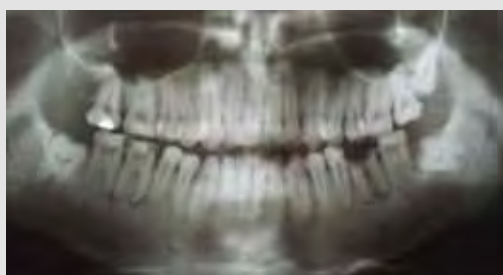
Panoramic radiography before treatment reveals a very thin enamel layer, normal roots and pulp chambers.
